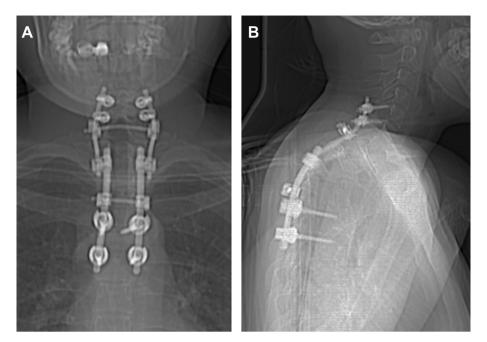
Computed tomography 20 months postoperatively showing good spinal alignment in the (A) anteroposterior and (B) lateral views.
